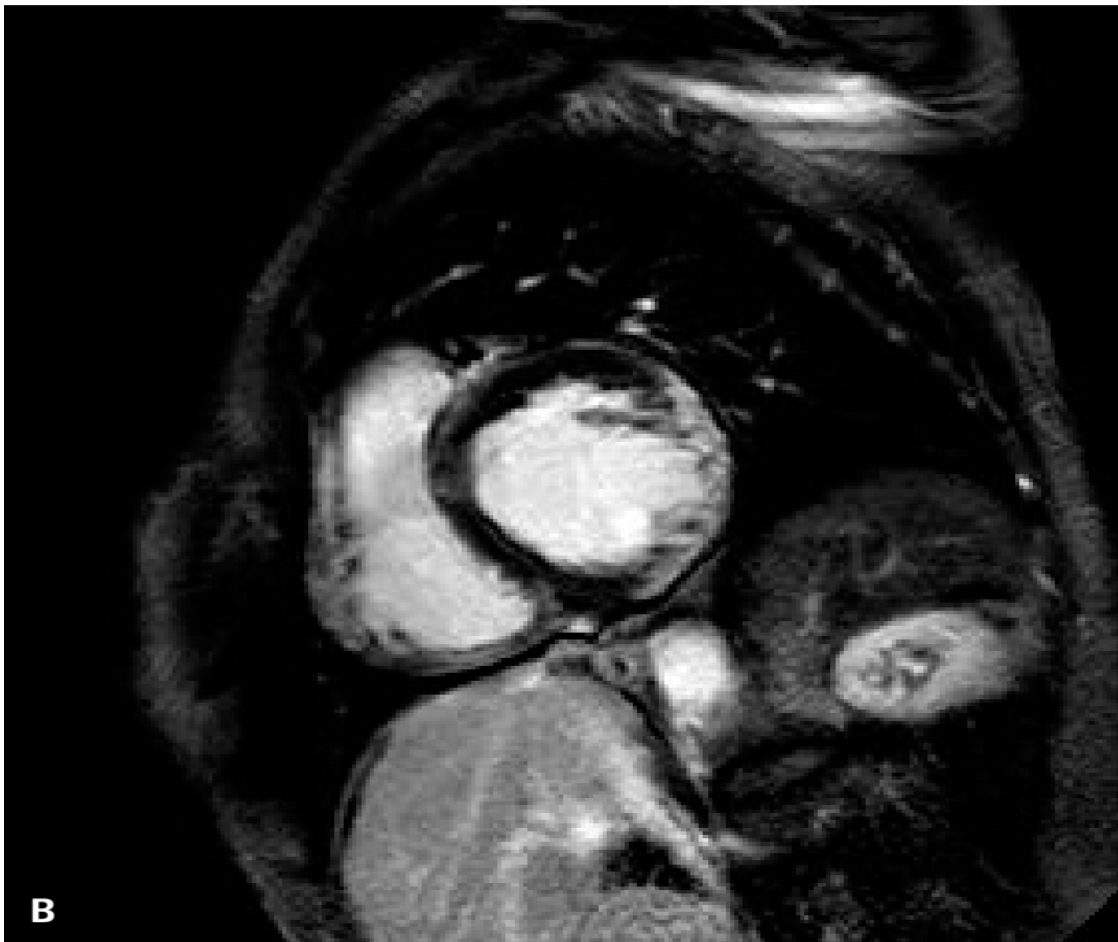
A. Transthoracic echocardiography showing severe left ventricular hypertrophy. B. Late gadolinium enhanced magnetic resonance imaging showing widespread septal enhancement
